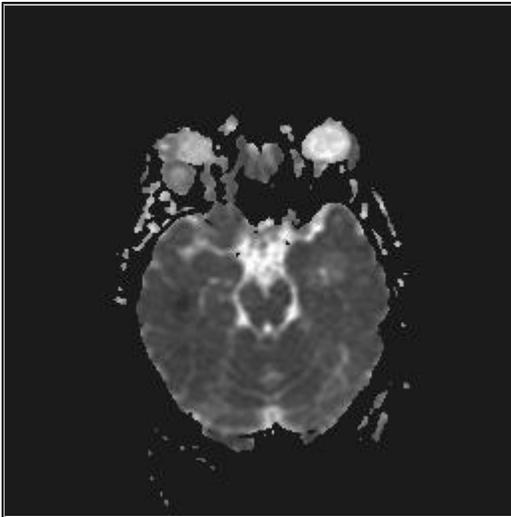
Diffusion weighted imaging (DWI)
